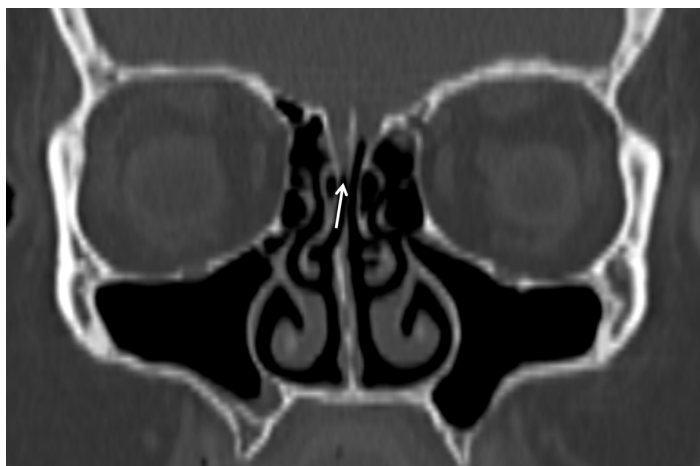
CT of paranasal sinuses in coronal incidence showing an inferior positioning of the cribriform plate of the ethmoid bone (arrow) in the right side in comparison with the left side. Surgical procedure confirmed the presence of a meningoencephalocele.
